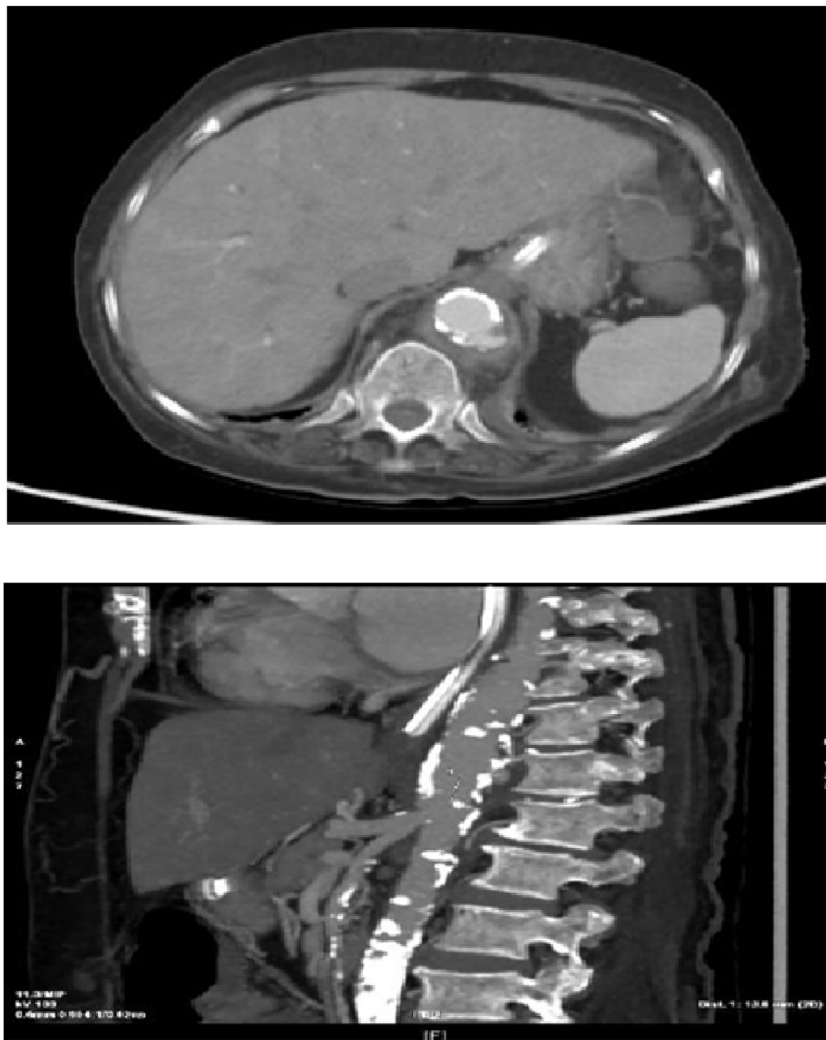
CT of the abdomen and pelvis with contrast at the time of presentation: Abdominal aortic ulceration with extravasation of contrast half inch from the level of the coeliac axis with proximal eccentric aortic thrombus noted.
